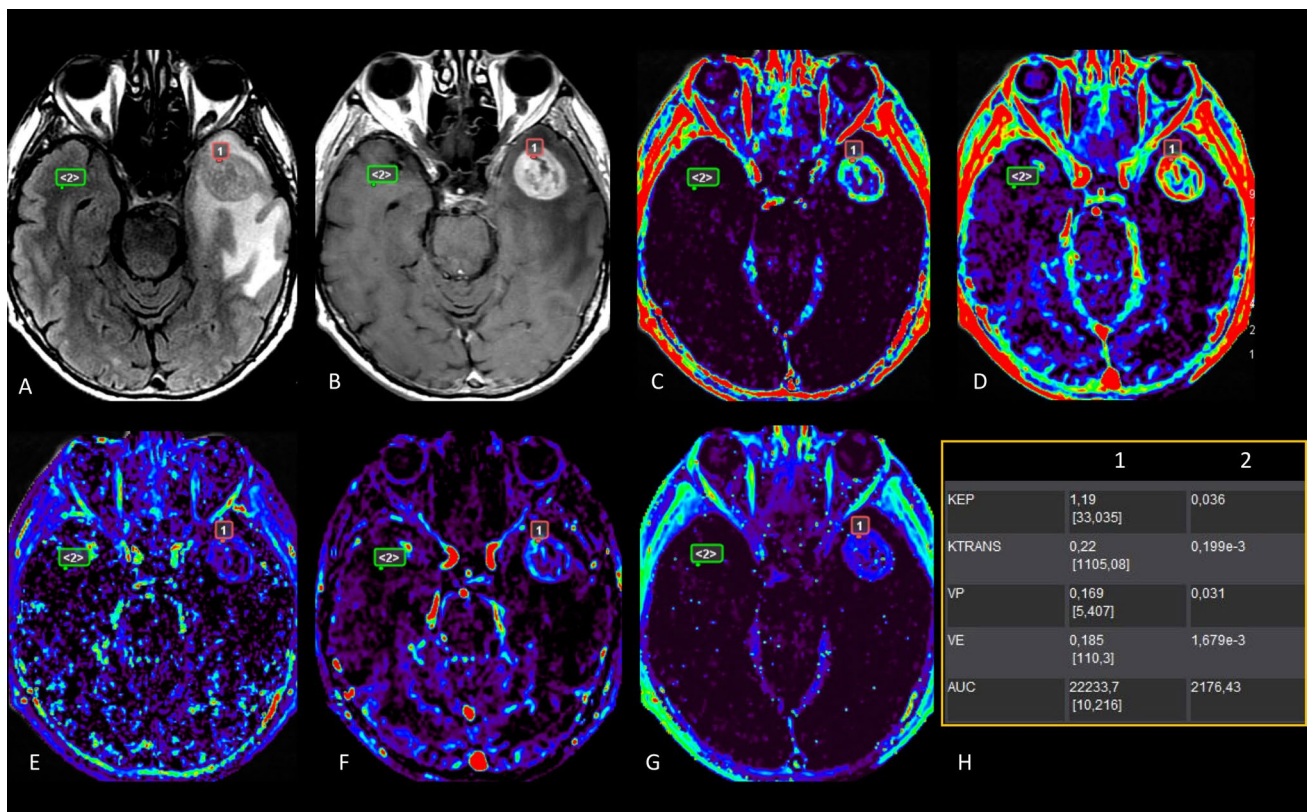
Glioblastoma WHO IV (high-grade glioma) in a 71-year-old man; morphologic imaging A FLAIR and B T1+Gd and parametric DCE maps C Ktrans, D AUC, E Kep, F Vp, G Ve, H summary of high perfusion values
